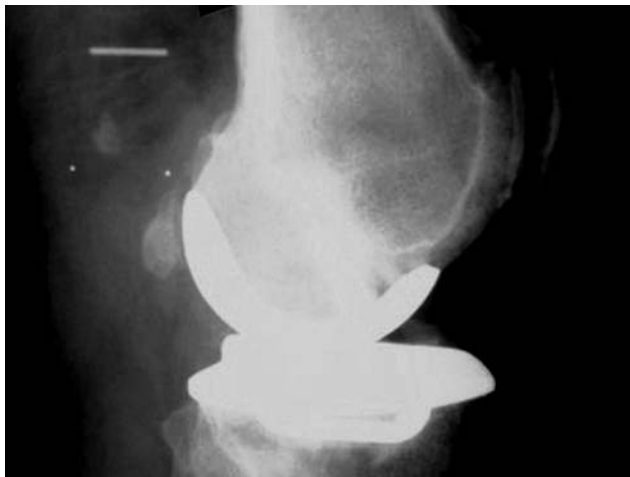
Lateral radiograph shown a posterior dislocation of the meniscal bearing PE implant
